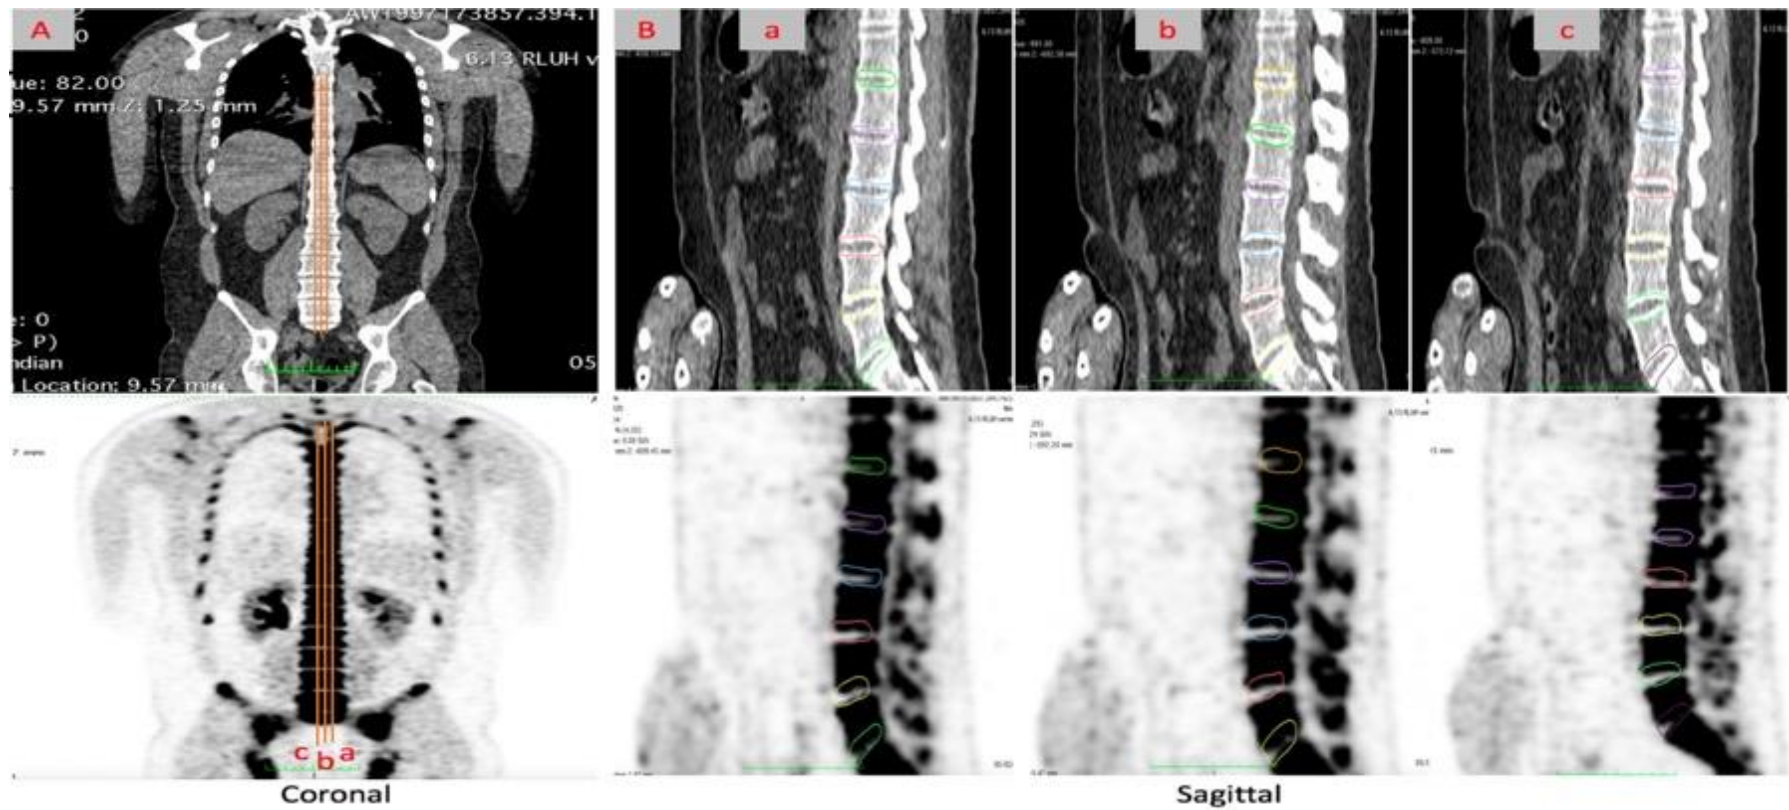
^{18}F -NaF PET/CT for the lower spine.
